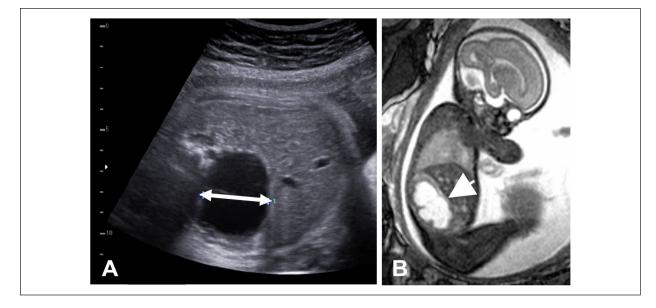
(A) Prenatal ultrasound of unilateral hydronephrosis (arrow). (B) Prenatal MRI of severe hydronephrosis (arrow).
